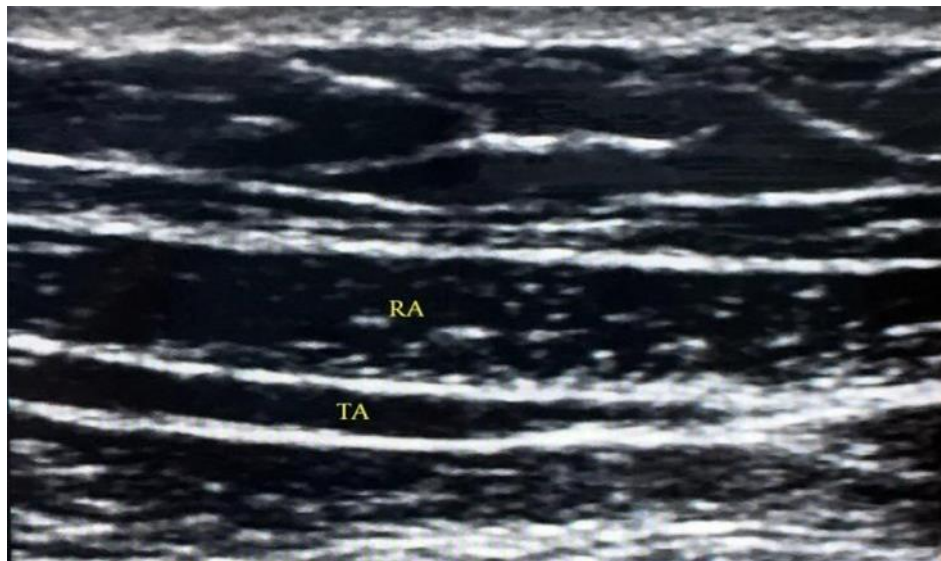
Transverse Abdominis Muscle As the ultrasound is directed down the costal margin, the transversus abdominis (TA) muscle comes into view. RA, rectus abdominis (40).
